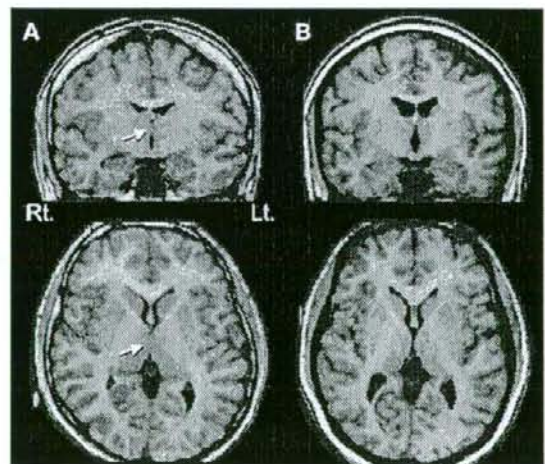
Coronal (upper) and axial (lower) views of the T1-weighted MR images (0.9375-mm slice thickness) in subjects with (A) and without (B) the adhesio interthalamica (AI). Arrows indicate the position of the AI.
